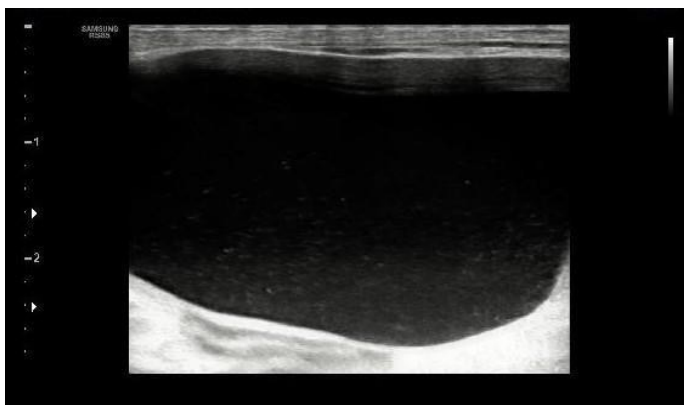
Ultrasonography of the abdominal cavity of the male African pygmy hedgehog. Distended urinary bladder with anechoic fluid and a small amount of echoic material, gravity-dependent
